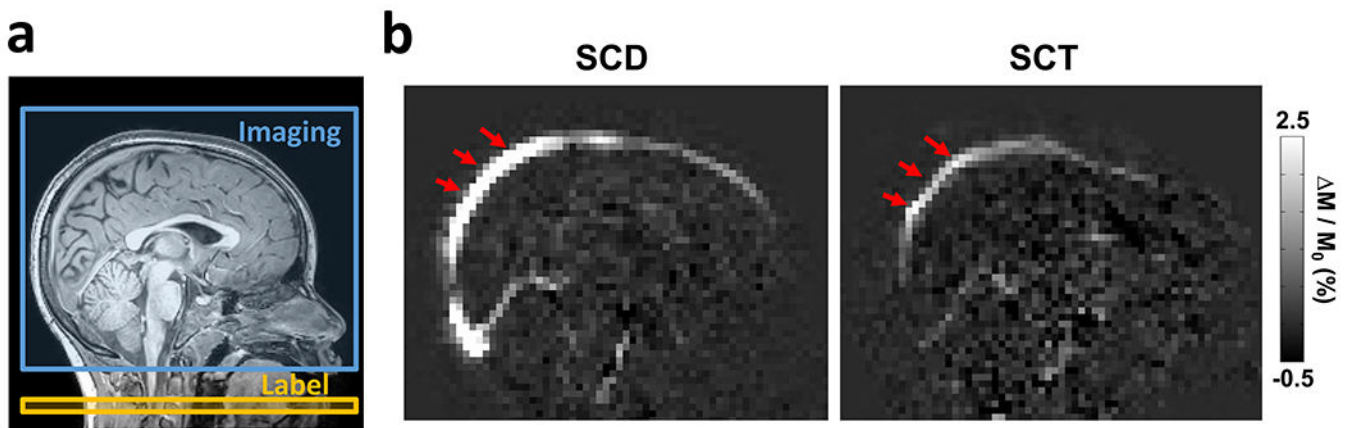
WEPCAST MRI for non-contrast assessment of BBB permeability to water. (a) Typical locations of labeling (yellow) and imaging (blue) slices in WEPCAST MRI. A mid-sagittal slice is used for imaging of ASL signal in superior sagittal sinus. (b) Representative WEPCAST images from a SCD (11yrs, female, hemoglobin SS) and a SCT (8yrs, female) participant. Red arrow indicates the superior sagittal sinus.
